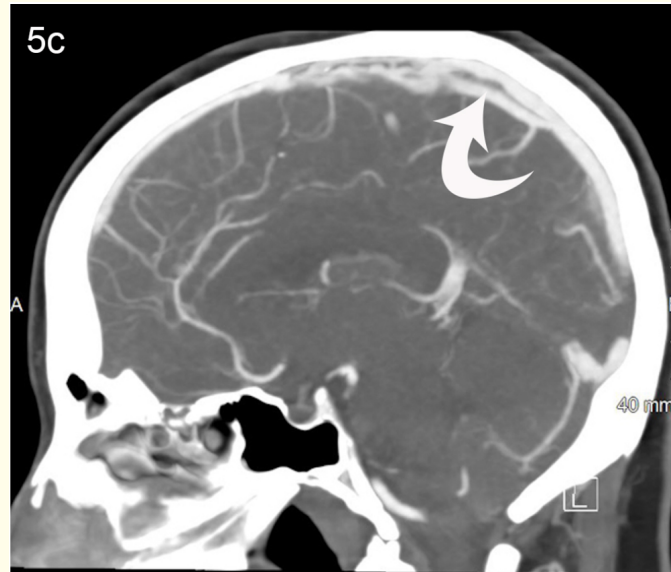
CT venogram [a-c]. Coronal (a), axial (b) and sagittal (c) post IV contrast reconstruction MIP images of CTV show filling defect in the superior sagittal sinus (curved arrow in a-c), enhancing left cortical vein of Trolard (straight arrow in a), region of non-enhancing right cortical vein of Trolard (arrowhead in a) and subtle hyperdense right frontoparietal parenchymal lesion (squiggly arrow in a).
